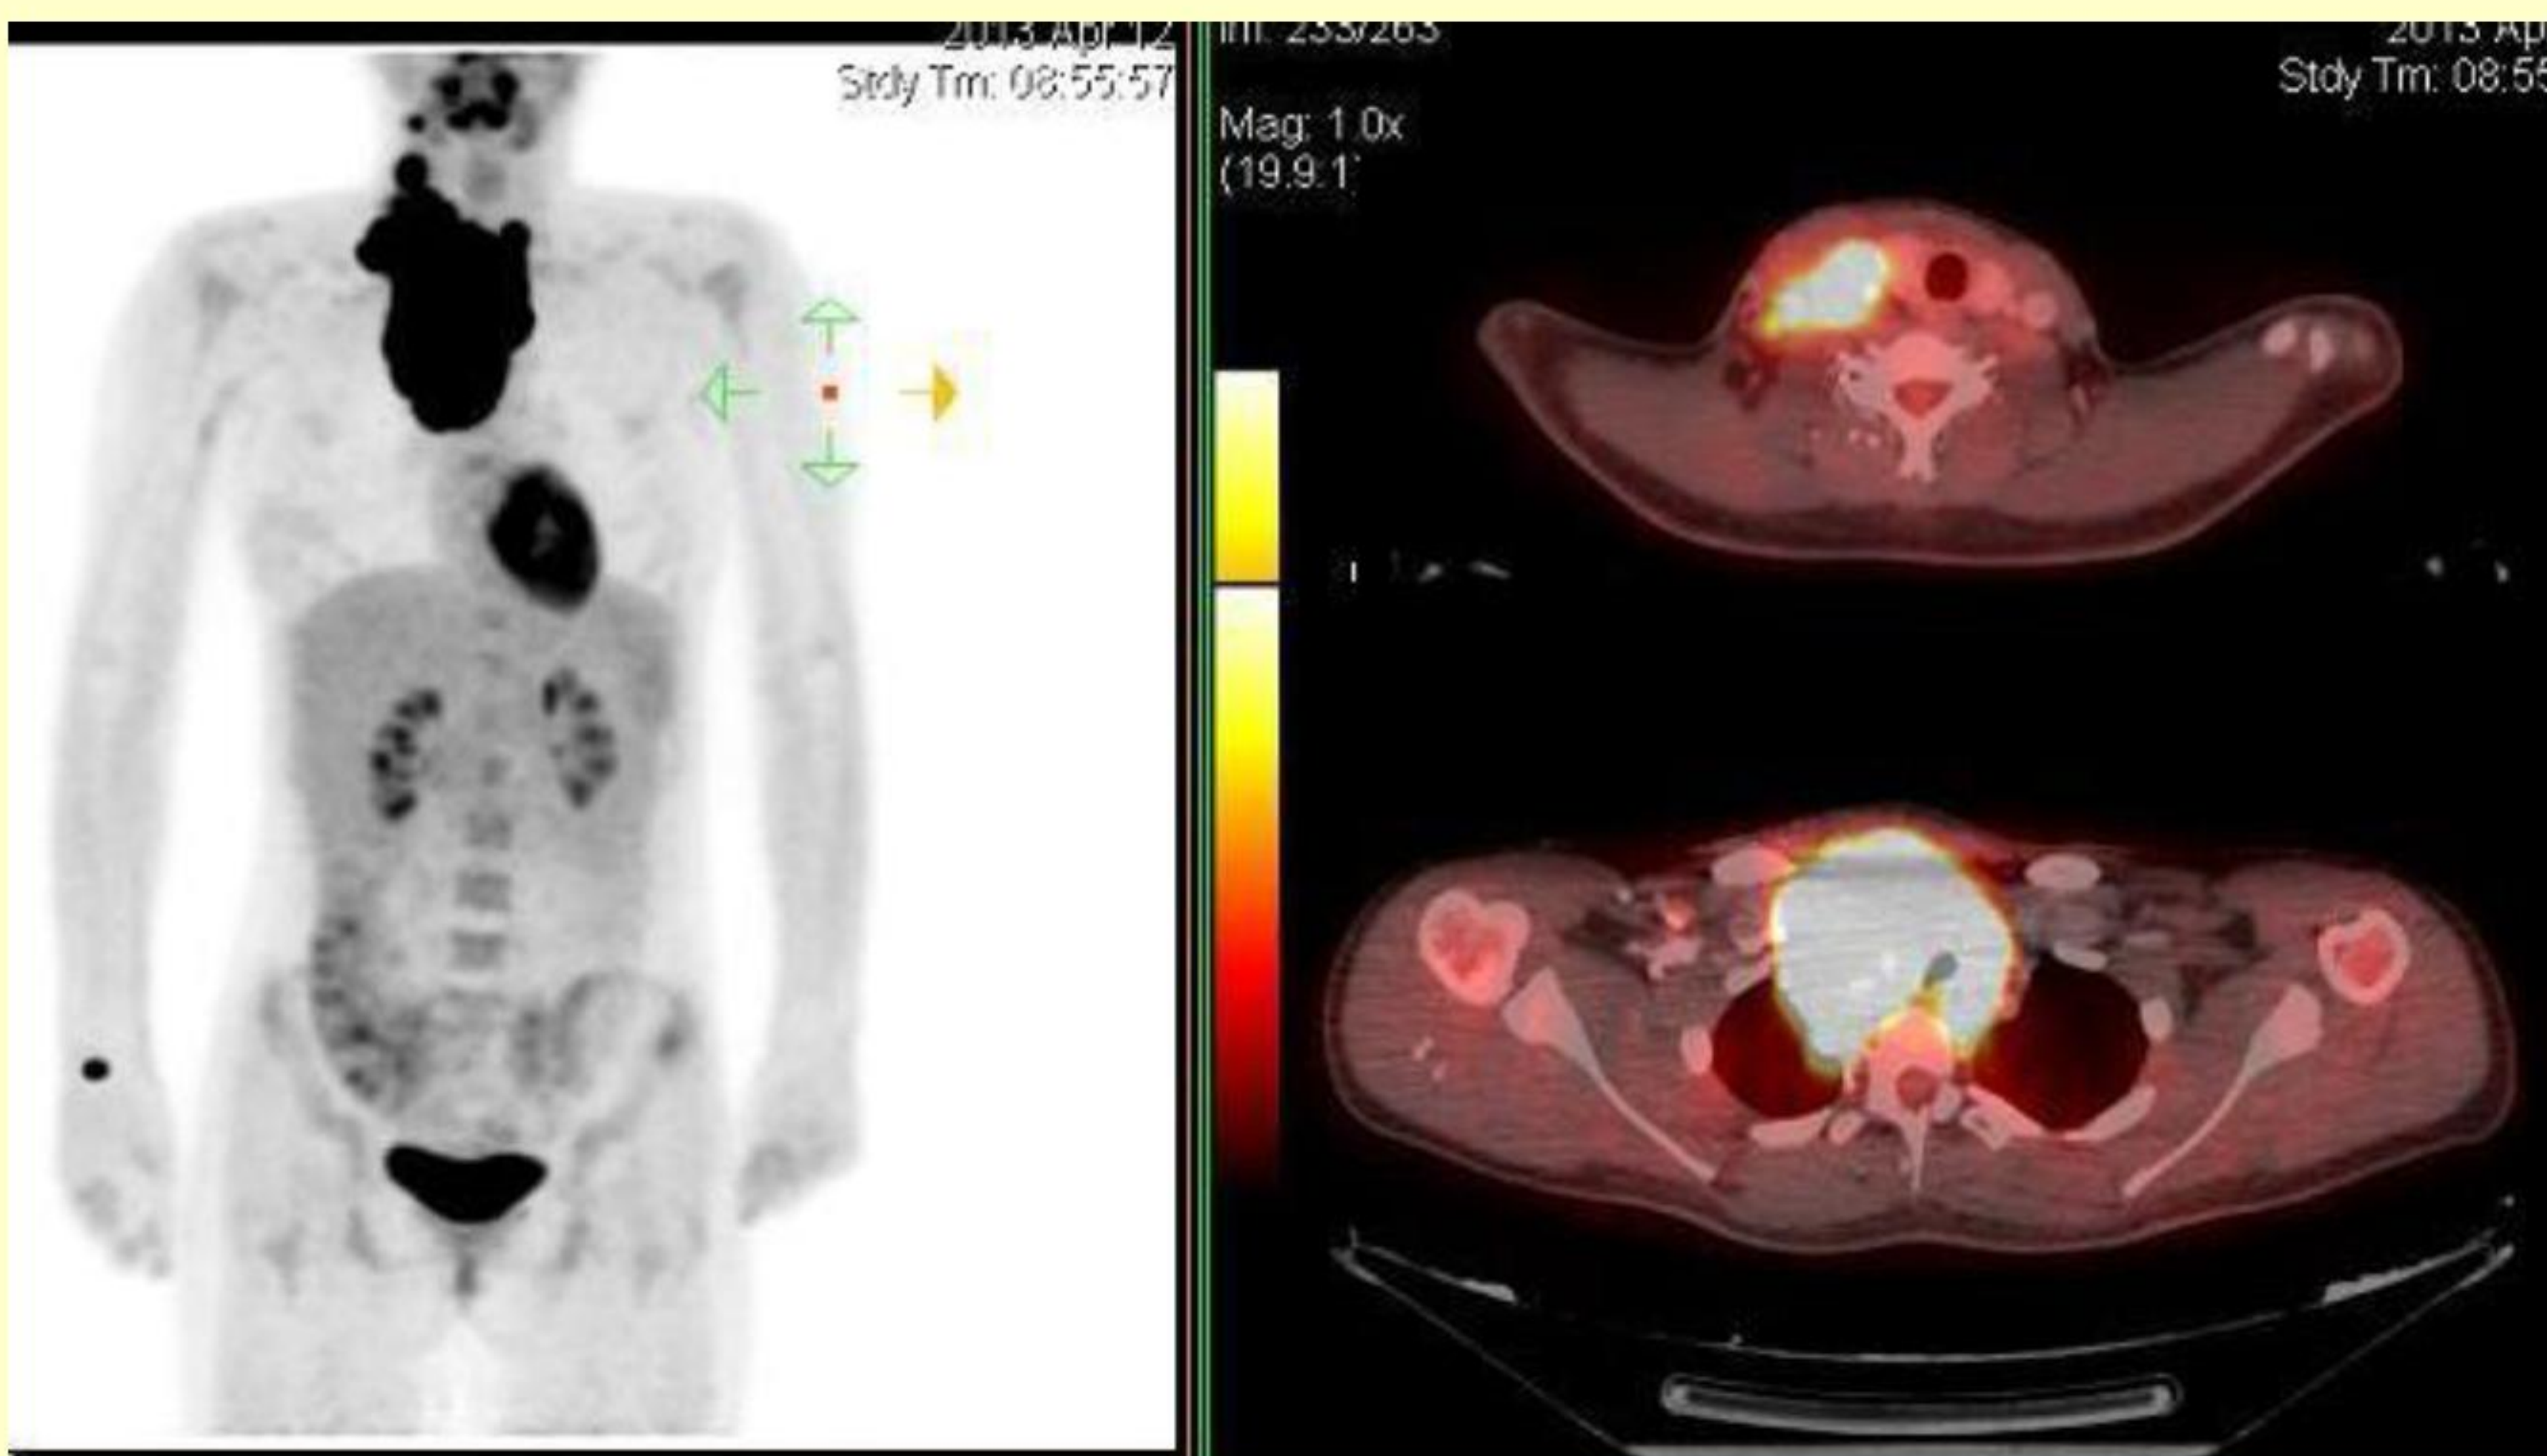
PET/CT scan with FDG positive signal, pathology in anterior mediastinum and neck structures. Staging of Hodgkin s lymphoma prior treatment.
